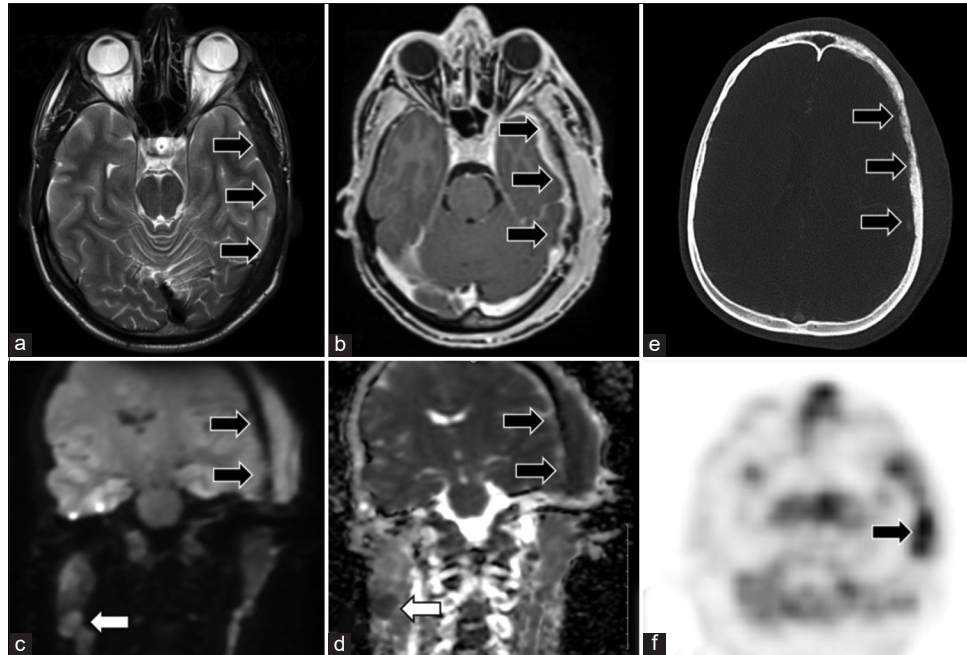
Multifocal calvarial, skull base, and facial osseous high-grade diffuse large B cell lymphoma in a 24-year-old male. Axial T2 (a) and axial 3D T1 MPRAGE after IV gadolinium administration (b) showed diffuse expansion, thickening and infiltration of the left fronto-temporal calvarial bones, associated with extra-cranial and intracranial enhancing masses (arrows). Coronal diffusion weighted image (c), and ADC (d), showed characteristic restricted diffusion of associated soft-tissue components. Axial high-resolution non-contrast CT head in bone window (e) demonstrated permeative pattern of osseous infiltration of the left fronto-temporal calvarial bones (arrows). Axial PET image (f) confirmed hypermetabolic activity of the mass (arrow).
